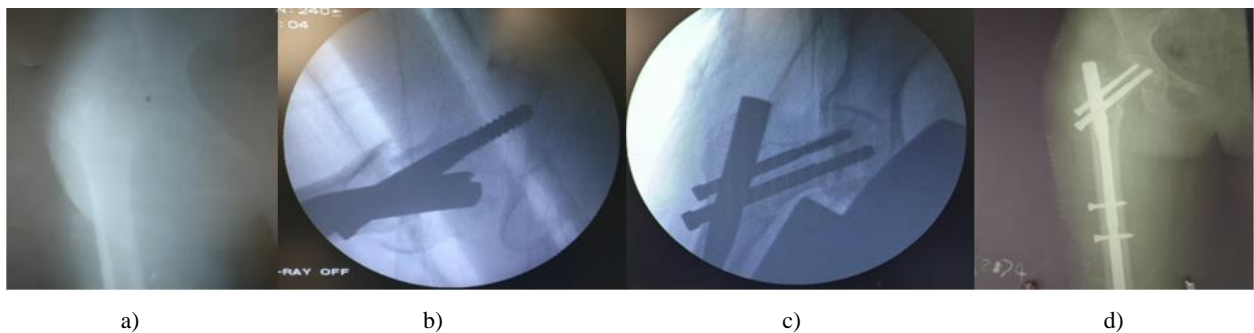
a) Boyd and Griffin classification type 2 intertrochanteric fracture b) & c) Intraoperative assessment of quality of fracture reduction appears to be good as per Baumgartner's criteria. d) Post operative radiograph at 3rd month follow up
